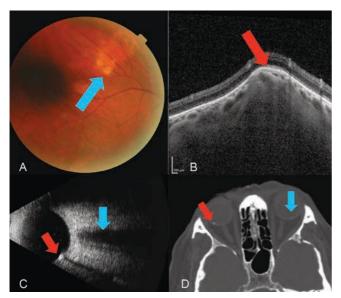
(A) Fundus photo of the yellow, subretinal lesion (blue arrow) located in the superior temporal quadrant of the right eye. (B) EDI-OCT (Spectralis, Heidelberg) through the SCC reveals a type 2 "rolling" lesion. Note the choroidal thinning above the lesion (red arrow). (C) B-scan ultrasound using the 10MHz probe highlights the echo-dense SCC (red arrow) with acoustic orbital shadowing which appears much smaller but similar to the optic nerve which is shown above this area (blue arrow). A choroidal melanoma would demonstrate low to medium internal echoes. (D) A previously ordered CT scan on a patient with SCC of the right eye (red arrow) and a subtle one in the left (blue arrow), which was not visible on clinical exam. Though not necessary in this case, sometimes radiological testing can be a form of multimodal imaging.
